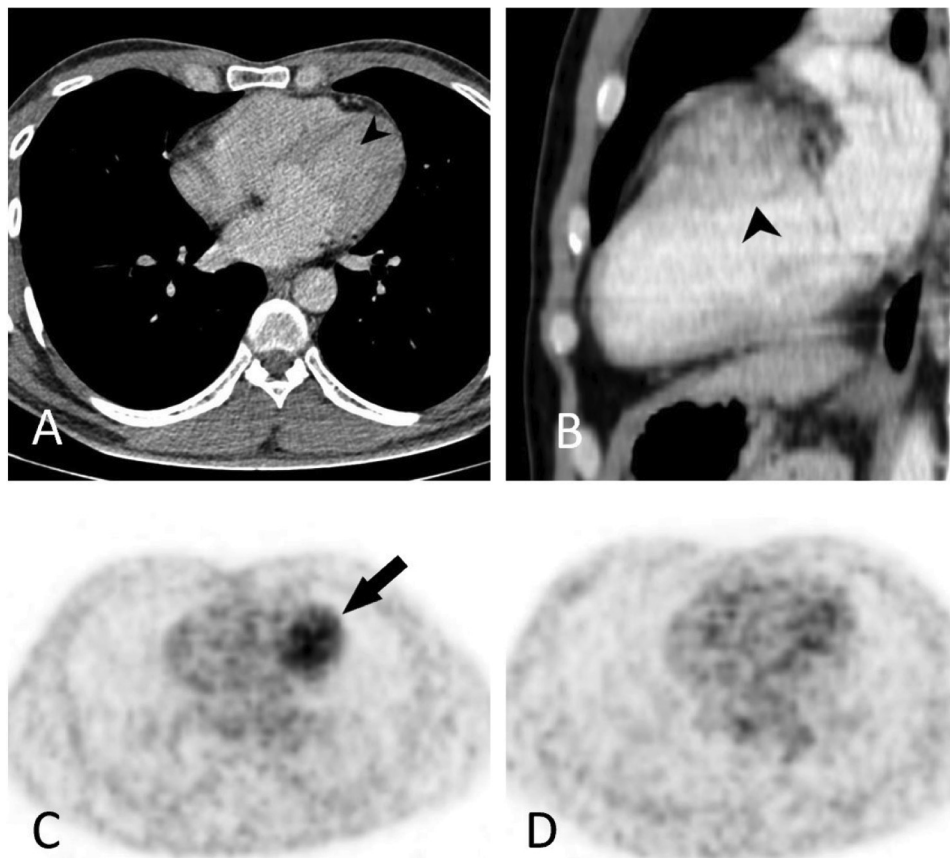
(A) Axial and (B) oblique sagittal contrast-enhanced computed tomography (CECT) images show an enhancing lesion (*arrowhead*) near the Left Ventricular Outflow Tract (LVOT). (C) Ga-68 DOTANOC positron emission tomography CT shows uptake in the lesion (*arrow*) with (D) no uptake noted in the rest of the myocardium.
